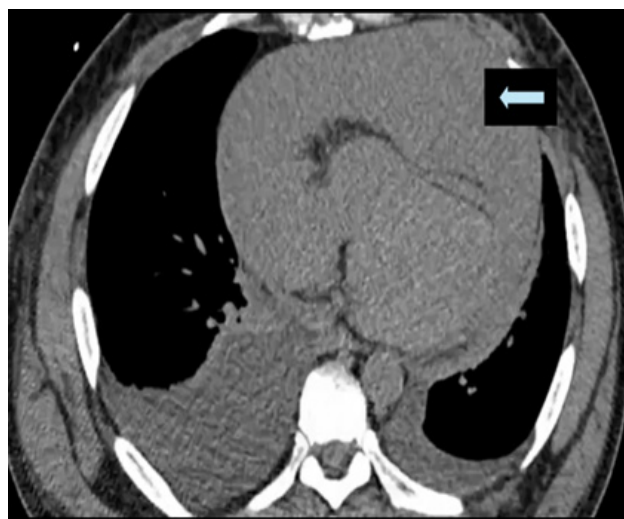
Axial CT demonstrating new large pericardial effusion with tamponade.
